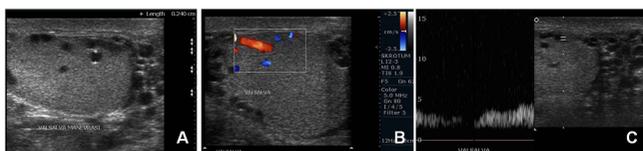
Longitudinal gray scale sonogram of the left testis demonstrates anechoic cystic and tubular structures within the testis (A). Color Doppler image shows presence of coloration in round and tubular structures with Valsalva maneuver (B). Duplex sonography showed the presence of venous flow pattern with Valsalva maneuver, within intratesticular varicoceles. Note the associating extra testicular varicoceles (C).
